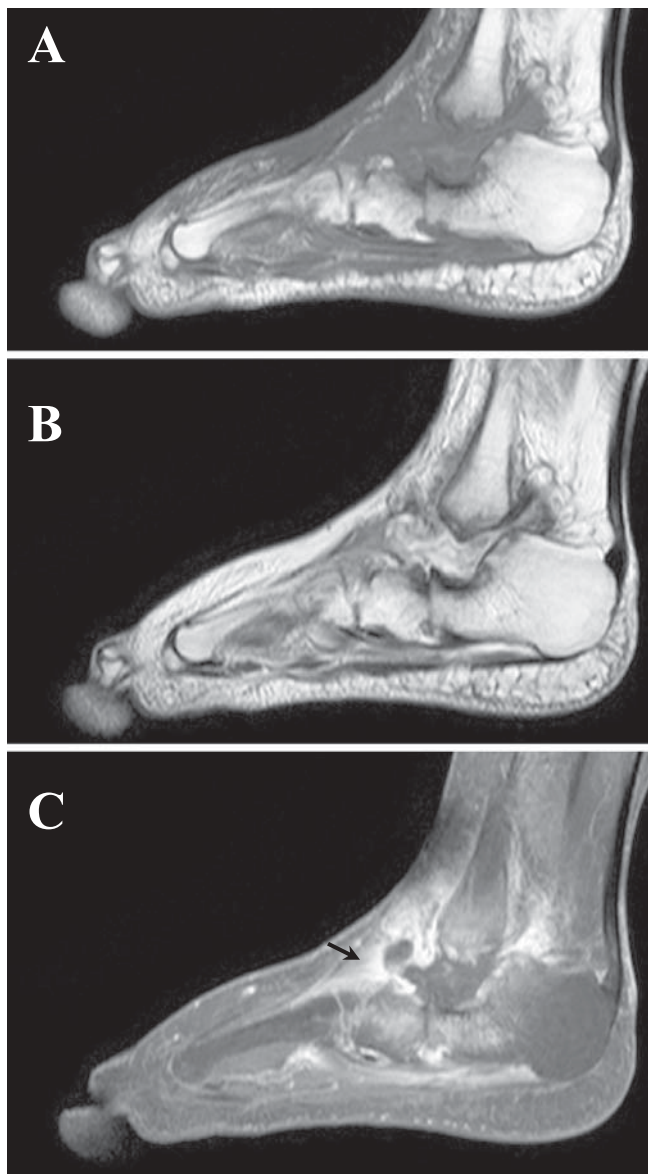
Magnetic resonance imaging of the right ankle. Sagittal T1 (A) and T2-weighted sequences (B) show marked effusion. (C) Contrast media enhancement of the diffusely enlarged and thickened synovia (arrow) following intravenous administration of gadolinium
